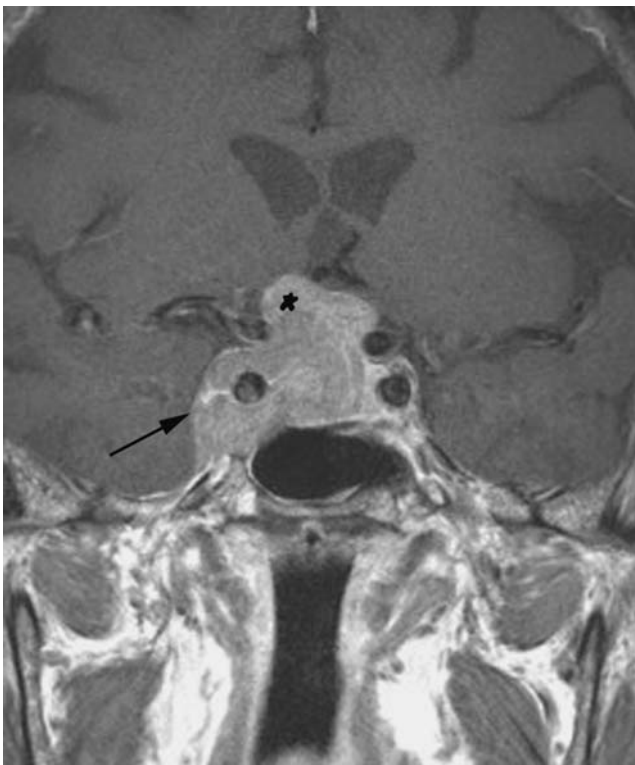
Pituitary macroadenoma. Coronal post-gadolinium MR image demonstrates a large mass in the sella with suprasellar extension (*black asterisk*) as well as extension into the right cavernous sinus (*arrow*)
